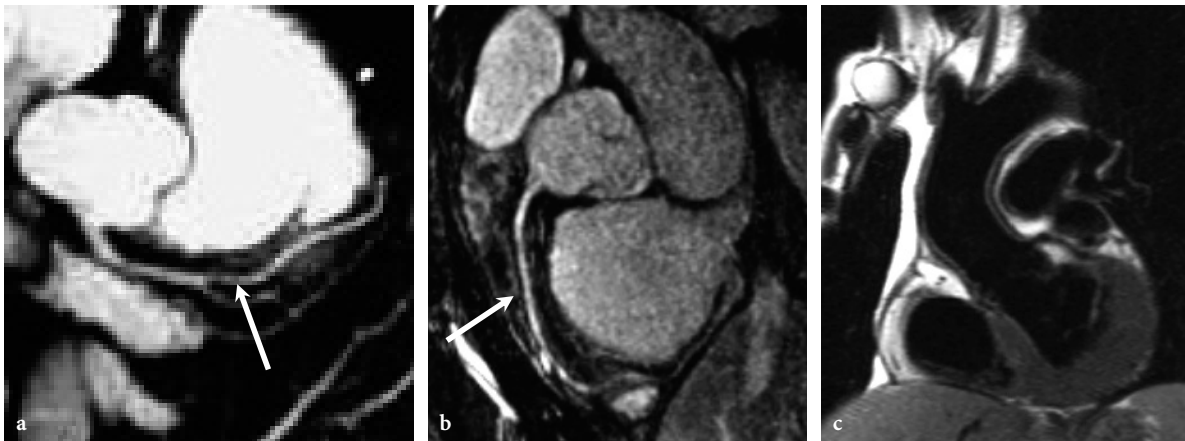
Cardiac MRI of the left coronary artery (LCA) (a) and RCA (b) with 2D-breath-hold bright-blood technique (c) and of the general cardiac morphology, showing arteritis in the ascending aorta, with the TRUE-FISP black-blood technique. (Images courtesy of the MRI division, Siemens, Erlangen, Germany)
